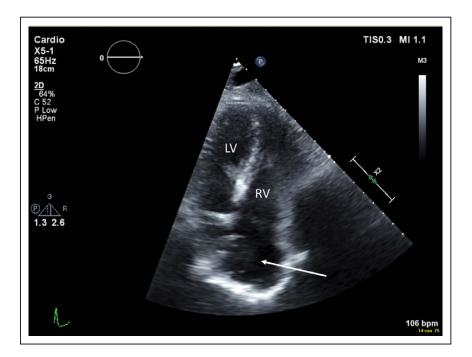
Transthoracic echocardiographyderived image focusing on the mass in the right atrium (arrow).
